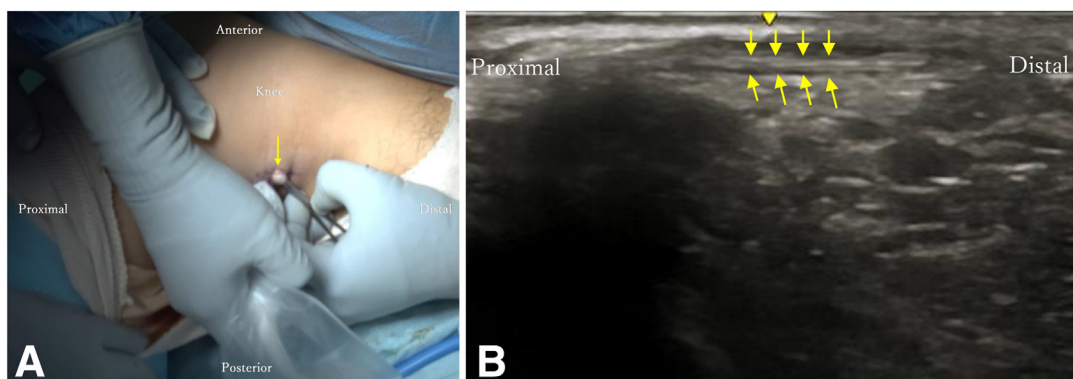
(A) Confirmation of the semitendinosus tendon. Left leg in a figure-4 position with the patient supine. Ultrasound is used to confirm that the structure caught with the mosquito forceps is a tendon (arrow) before completely pulling it out. (B) Long-axis ultrasound image of the semitendinosus tendon (arrows).
